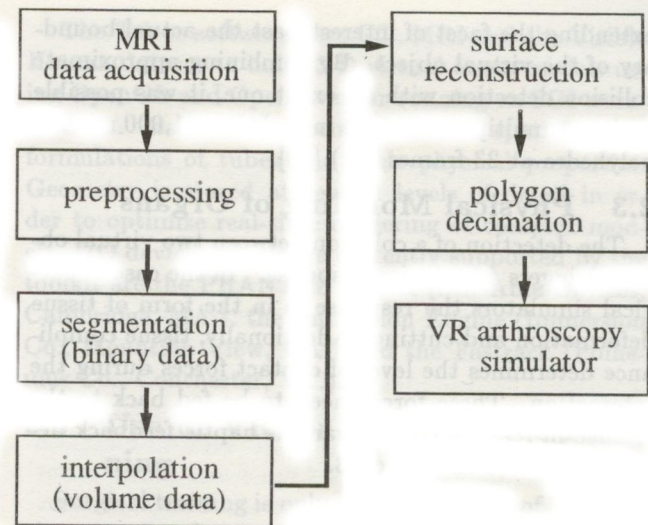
Organ modeling based on segmentation of 2-D MRI data [Bauer et al., 1995]
